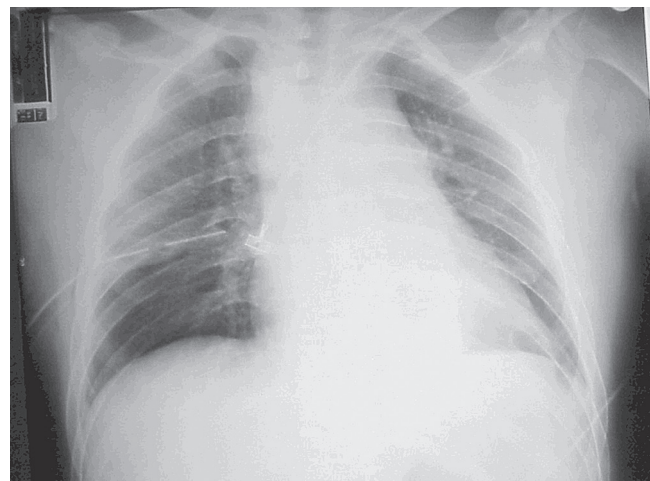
■ Typical chest radiograph with widened mediastinum suggestive of aortic transection from decelerating blunt chest injury.
